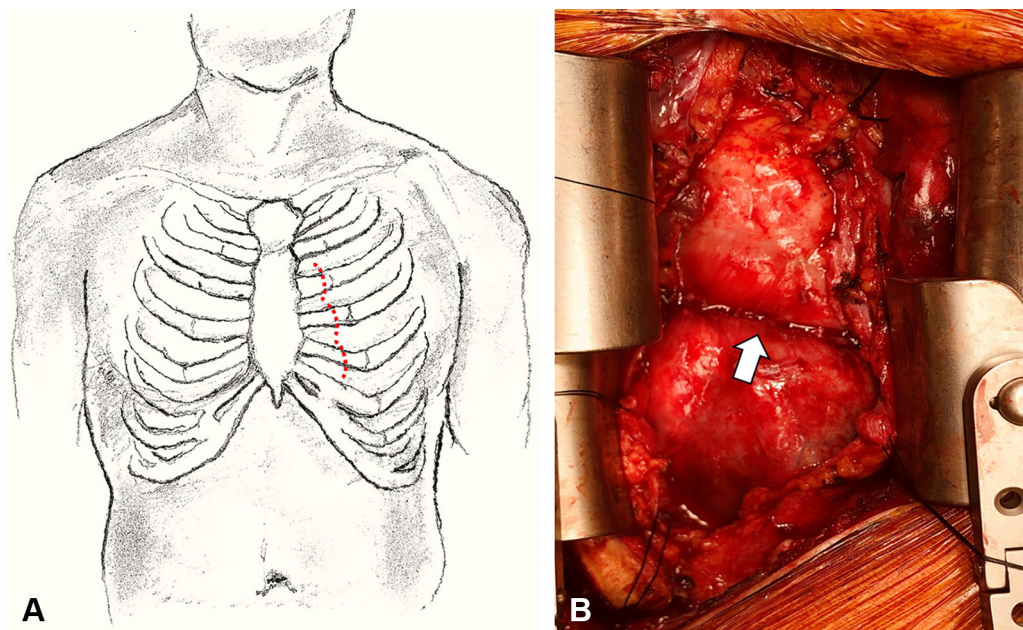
A, Left parasternal approach: dividing the left third to fifth costo-chondral cartilages (*dotted line*) after lower midline skin incision. B, Prominent “adhesion band” (*arrow*) forming a local constriction on the RV, which appeared to be caused by direct bar compression.
